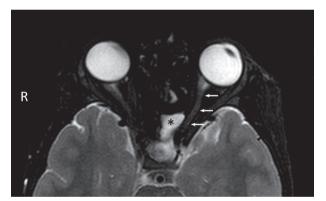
MRI axial T2-weighed sequence showing the optic nerve (arrows) running just superiorly and laterally to the sphenoid sinus, in close proximity to the infectious focus (asterisk).
